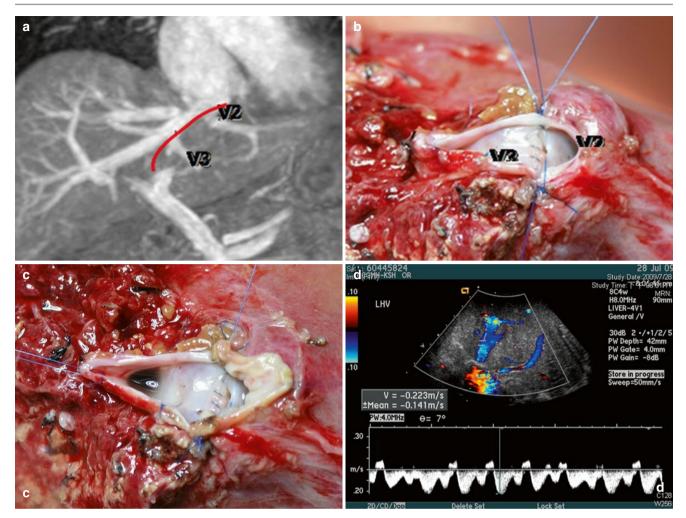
(a) Separate V2 and V3. (b) V2 and V3 harvested individually and a graft venoplasty has been done. (c) A cryopreserved vein patch has been used. (d) Doppler ultrasound after reconstruction shows triphasic waveforms in the recipient hepatic veins
